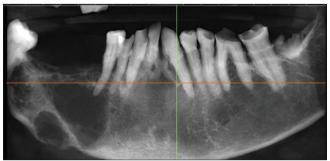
Orthopantomogram revealing multilocular radiolucency
